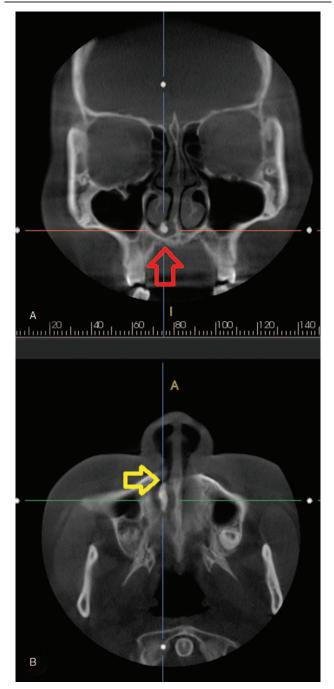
Computed tomography of the osteoma with actinomycosis in the nasal cavity. (A) Coronal view of the right nasal cavity showing an approximately $0.5 \times 0.5 \, \mathrm{cm}$ ossified mass in the right nasal cavity (red arrow). Note the soft tissue density adjacent to the right inferior turbinate. (B) Axial view of the right nasal cavity showing an approximately $0.5 \times 1 \, \mathrm{cm}$ ossified mass in the right nasal cavity (yellow arrow). There is no bone destruction or invasion.
